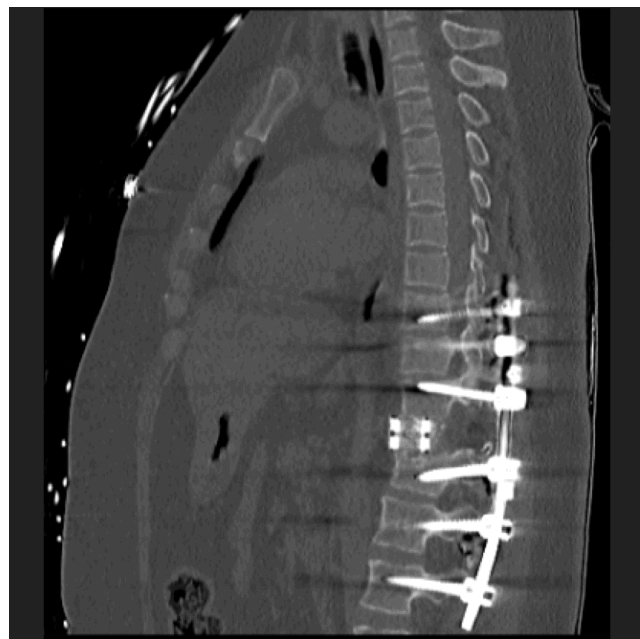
Post-operative spine CT showing T11 VCR and reconstruction with vertebral body cage and T8-L3 pedicle screws fixation.
